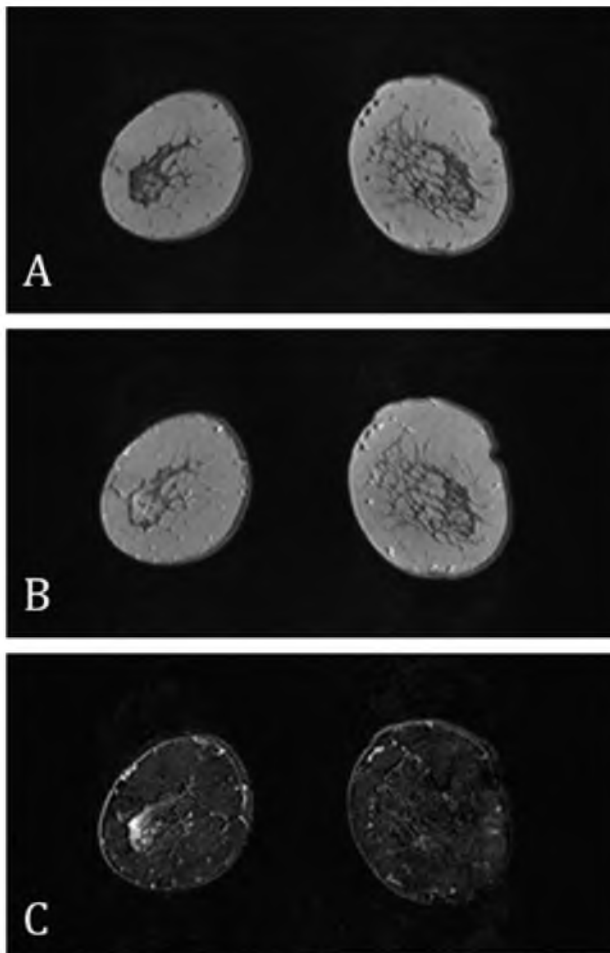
Coronal T1 weighted breast MRI of both breasts. In the left breast a 3.6 cm ILC is present. The tumor is hardly visible without contrast (A), but clearly enhances after contrast administration (B), although differentiation from fatty tissue is still difficult without unenhanced images. Subtraction of the unenhanced MRI from the contrast enhanced MRI nulls the fat signal and clearly shows the enhancing tumor (C).
